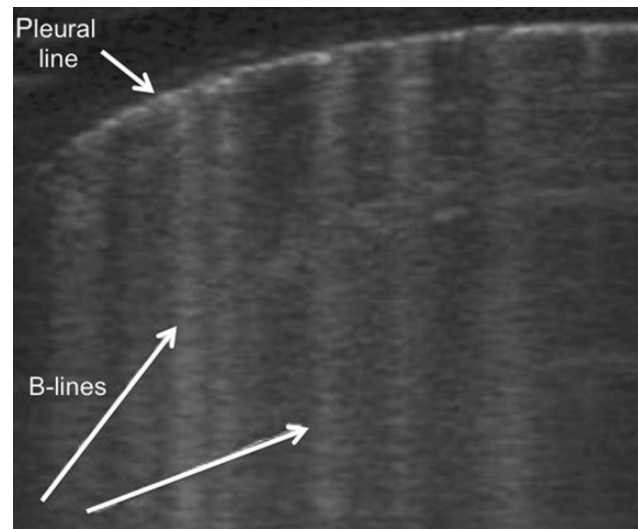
Sonographic B-lines: the sign of pulmonary interstitial syndrome.
